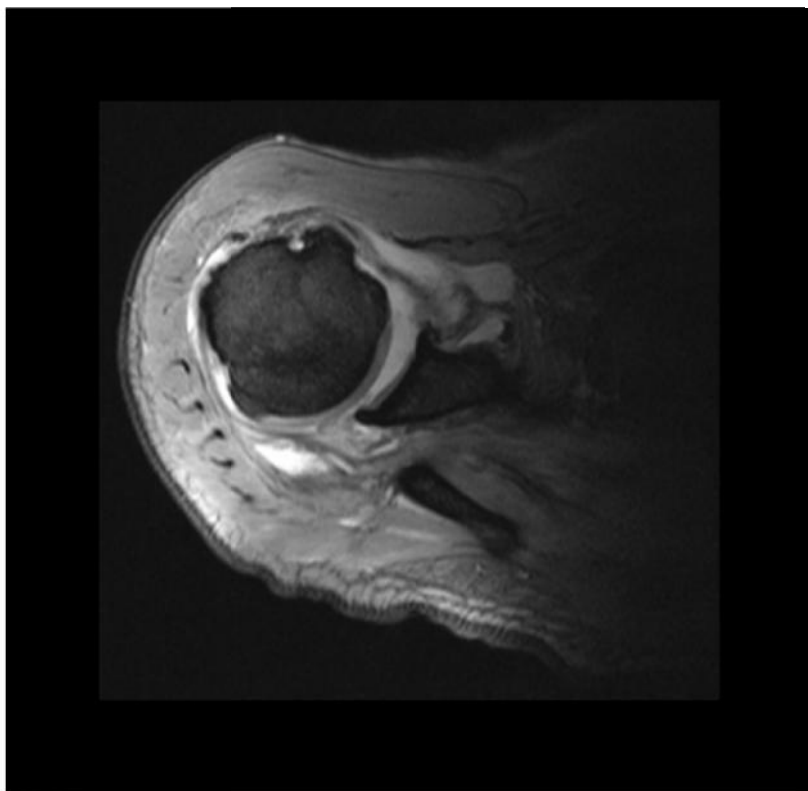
MRI Gadolinium axial cut shows similar joint effusion which is also suggestive of intraarticular collection in support of infective process
